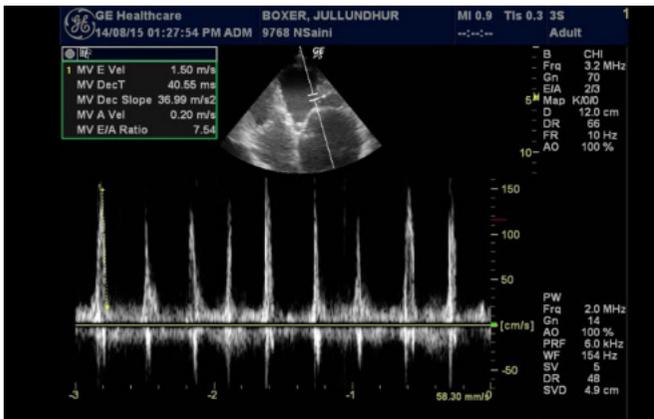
Pulse wave doppler of mitral valve indicating restrictive filling pattern
